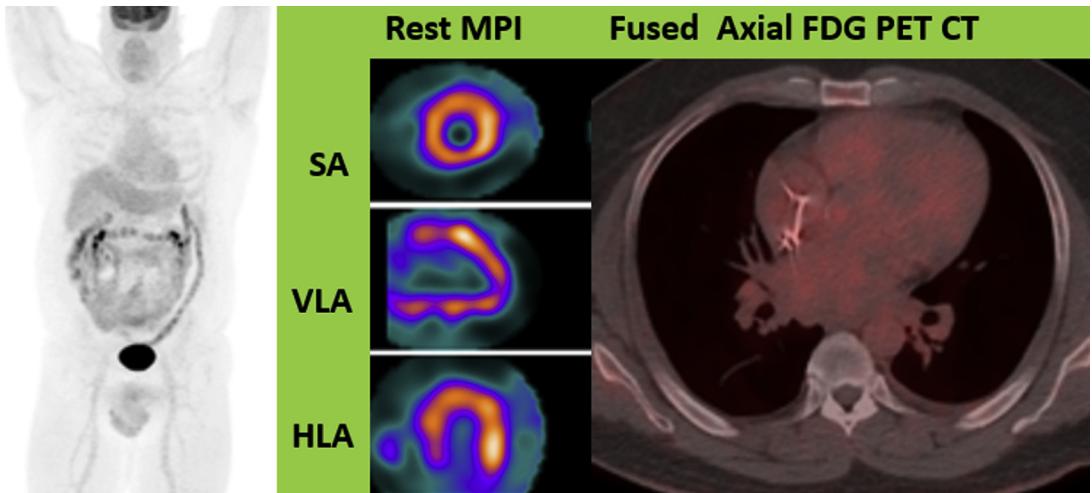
A 49-year-old man with sarcoidosis and complete heart block, post-pacemaker placement, on immunosuppressive treatment. Stage 1 CS with normal Technetium-99m (99mTc) rest myocardial perfusion (*center panel*) and no active cardiac or extracardiac inflammation on MIP (*left panel*) and fused FDG PET/CT images (*right panel*). SA: Short Axis, VLA: vertical Long Axis, HLA: horizontal long axis.
